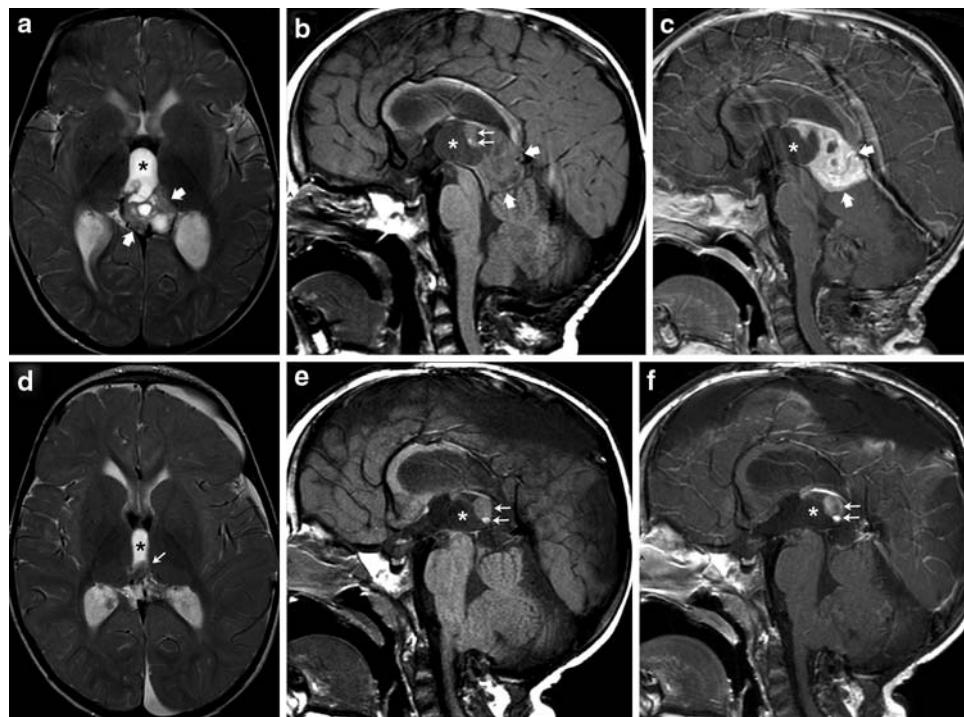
Neuroradiology. a–c MRI at presentation: a axial T2-weighted image, b sagittal T1-weighted image, c contrast-enhanced sagittal T1-weighted image. A huge neoplasm involves the pineal region and posterior third ventricle. There are a large, anterior cystic component (*asterisks*, a, c) and a posterior solid component (*thick arrows*, a, c) containing multiple necrotic areas, visible as T2-hyperintense areas that do not enhance with contrast. Along the posterior aspect of the cyst there are a larger, T1-isointense, superior
